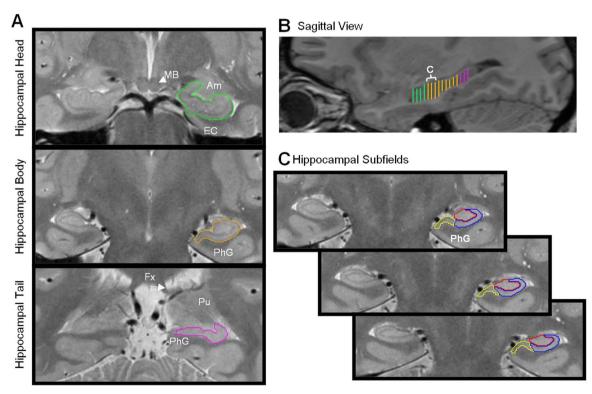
Example manual tracing of hippocampal subfields and head, body, and tail on T2 proton-density weighted turbo spin echo images. Image intensities are inverted. (A) Example of manual tracing of hippocampal head (green), body (orange), and tail (purple). (B) An example sagittal T1-weighted image that displays the approximate range of head (green), body (orange) and tail (purple) measurements made from the T2-weighted images. The white bracket, labeled "C" indicates approximately the 3 slices on which the subfields were segmented in the anterior Hc body, beginning posterior to the uncal apex. (C) Example of manual tracing of the hippocampal subfields were made on three contiguous slices of the anterior body on T2 proton-density weighted turbo spin echo images: subiculum (yellow), CA1-2 (blue), CA3-dentate gyrus (red). Additional regions are labeled for anatomical reference: Am—amygdala; EC—entorhinal cortex; Fx—column of fornix; MB—mammillary body; PhG—parahippocampal gyrus; Pu—pulvinar nucleus.
